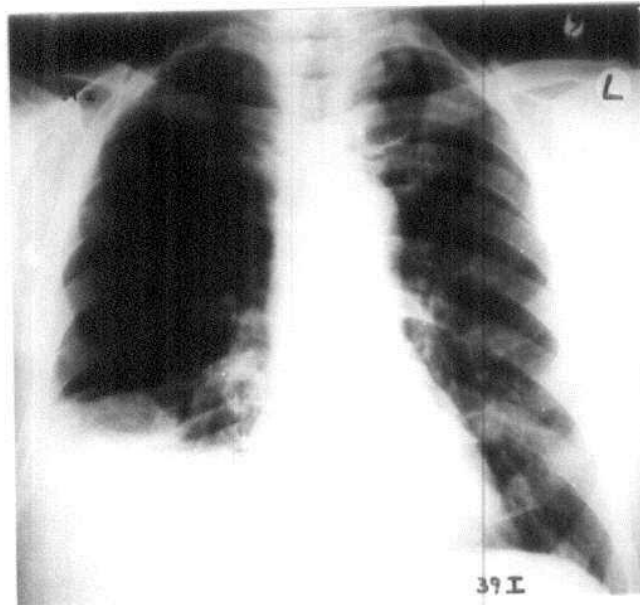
Postoperative chest radiograph for patient No. 39 I (two weeks after surgery): showing right basal lung opacity with right pleural collection. The right coupla is high with sluggish movement by fluoroscopy. The picture suggested right subphrenic collection (confirmed by ultrasonography).
